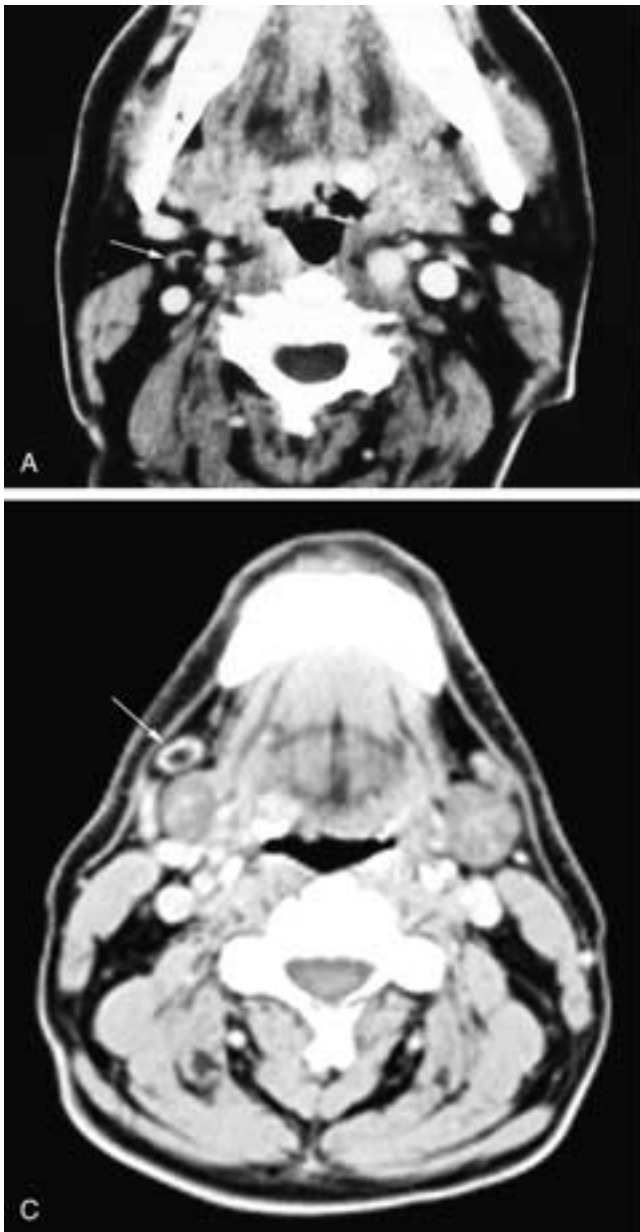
Axial contrast-enhanced CT scan (A) shows a comma-shaped left level II node (*arrow*) that has fat in its hilum along its medial margin. This is a normal-sized, reactive node with fatty metaplasia at its hilum secondary to exposure to chronic inflammation. Axial contrast-enhanced CT scans from cranial (B) to caudal (C) on another patient show a right level I node (*arrow* in B and C) that in C appears to have central necrosis. However, in the adjacent image (B), fat in the nodal hilum is seen, indicating that this is a reactive node. There also is a left level I reactive node with fat in its hilum seen in B.
